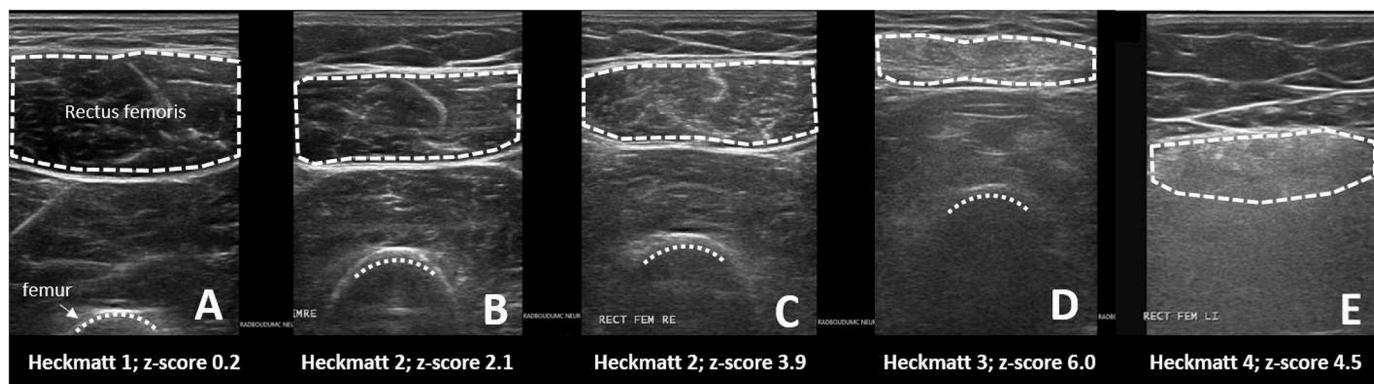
Ultrasound images of the right rectus femoris of FSHD patients and their Heckmatt and echogenicity z-scores.
